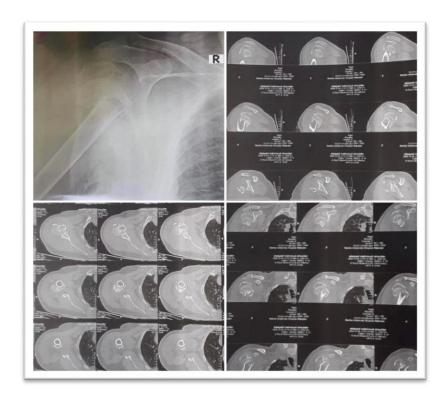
Preoperative X-Ray and CT images for male patient 55 years old with 4-part proximal humeral fracture. Patient had normal pre-injury level of activity.
